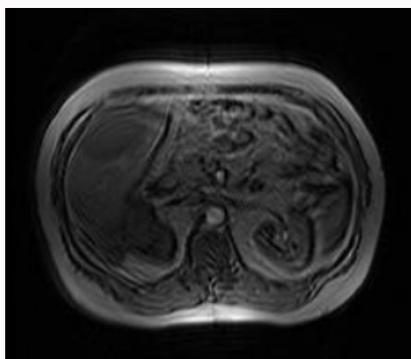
Transverse view of Abdominal MRI.
